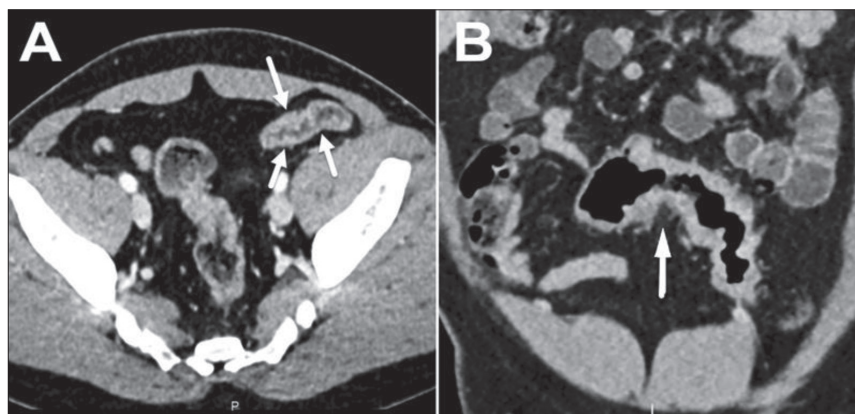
Contrast-enhanced axial (A) and coronal (B) CT scans showing the segmental (white arrows) thickening of the sigmoid colon wall highly suspicious of a neo-infiltrative process, but without clear visualization of multiple polyps on the mucosa
